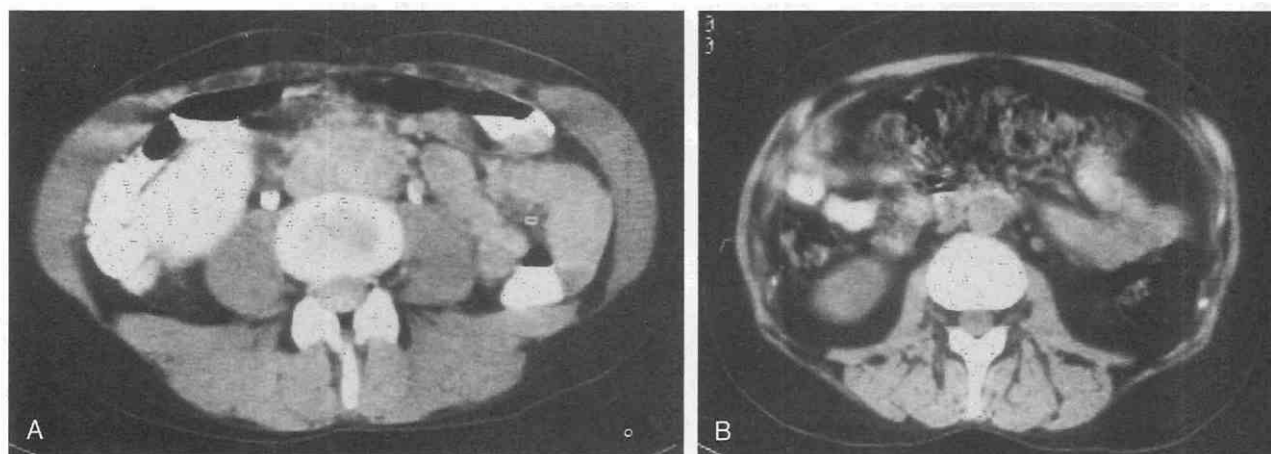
Retroperitoneal fibrosis. A, Nondynamically enhanced CT scan reveals a soft tissue mass enveloping the aorta and inferior vena cava. B, An unenhanced scan obtained after 3 months of corticosteroid therapy shows almost complete dissolution of the plaque. The increase in retroperitoneal fat is a result of corticosteroid use. (From Degesys GE, Dunnick NR, Silverman PM, et al: Retroperitoneal fibrosis: Use of CT in distinguishing among possible causes. *Am J Roentgenol* 146:57-60, copyright by American Roentgen Ray Society, 1986.)
